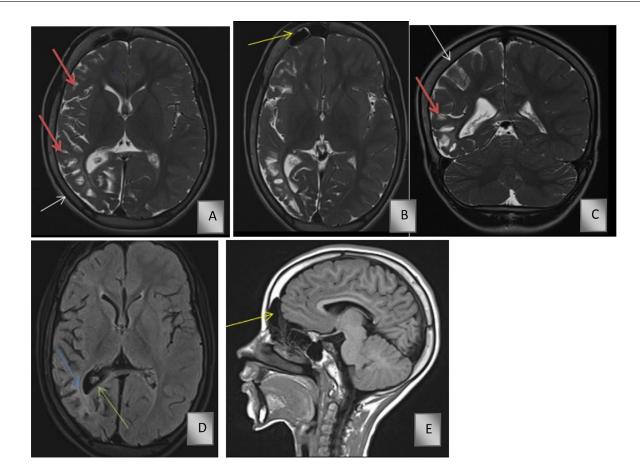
Axial (A and B) and coronal (C) T2-weighted images demonstrate: enlargement of the subarachnoid spaces of the right convexity (red arrows), of the sylvian fissure, discrete enlargement of the choroidal fissure. Axial (D) FLAIR: signal anomaly in the right hemispheric cortico-subcortical area (blue arrows) responsible of attraction on the occipital horn of the lateral ventricle (green arrow) in relation to an area of gliosis. Sagittal (E) T1: frontal sinus is hyperpneumatized (yellow arrow) with hypertrophy of cranial vault (white arrow).
